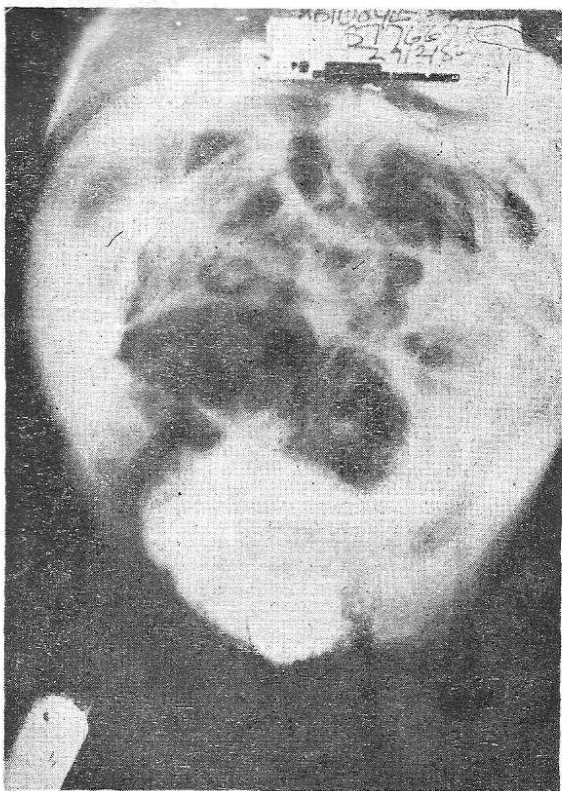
Abdominal radiograph obtained 10 minutes after MCU. There is generalised smearing of the peritoneum and viscera with leaked contrast medium (positive and contrast parietogram). Note the well-defined liver outline.
